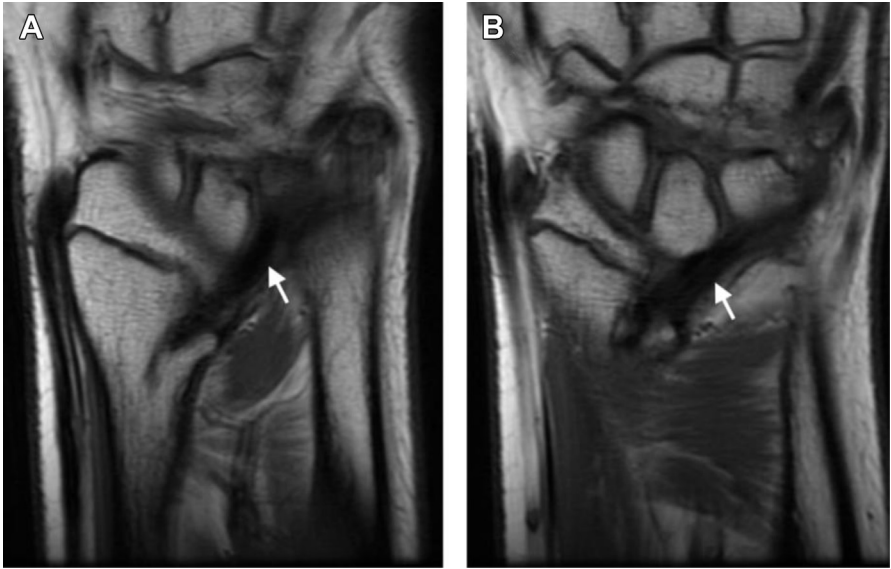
(A and B) demonstrate sequential coronal T1 weighted MRI images of the wrist in a patient with Leri-Weill Dischondrosteosis with a clearly visible Vicker's ligament (*white arrows*).
